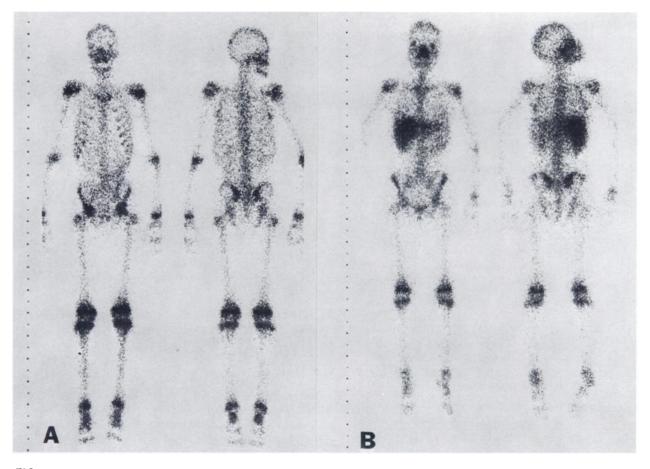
(A) Gallium-67 study of patient shown in Fig. 1 (anterior and posterior views). Note excessive osseous localization of radionuclide, and lack of hepatic uptake. Gallium study resembles bone scintigram except for lack of renal localization. (Ga-67 shadow in lower left abdomen is colonic.) (B) Gallium-67 study of 15-year-old girl injected with gallium citrate from same batch as patient shown in Fig. 2A. Her scintigram shows typical normal distribution of Ga-67.
